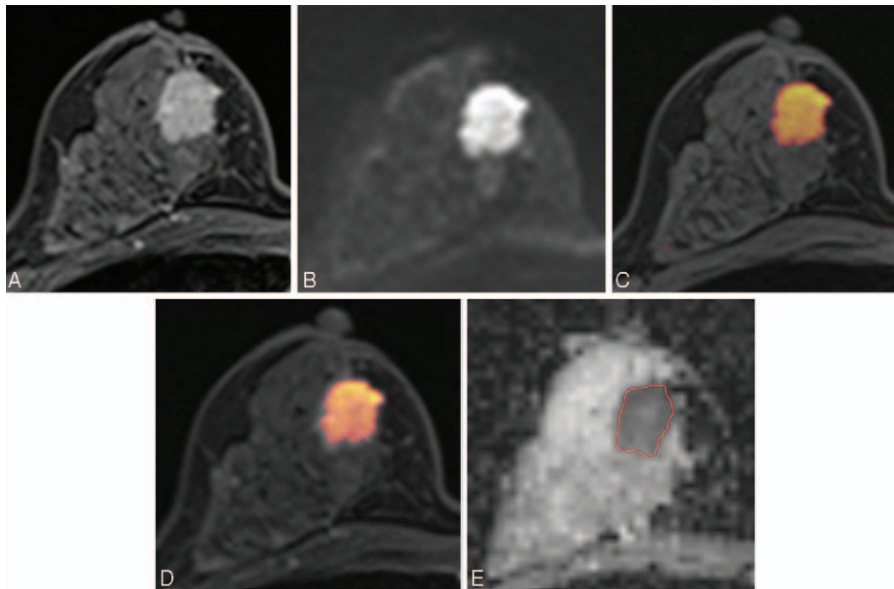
Images of a 45-y-old patient with an invasive ductal carcinoma of the right breast. (A) Axial dynamic-contrast enhanced MRI shows a 2 cm-enhancing mass in the right breast. (B) Diffusion-weighted image at 1000 s/mm² shows a high-signal intensity mass in the right breast. (C, D) For the corresponding lesion, axial UFMR (C) and PCFMR (D) also show a red-colored mass in the right breast. (E) ADC map shows a mass with low ADC value in the right breast of 0.844 × 10⁻³ mm²/s. Definitive surgery confirmed a 1.9-cm invasive ductal carcinoma. ADC = apparent diffusion coefficient, MRI = magnetic resonance imaging, PCFMR = fused diffusion-weighted imaging using early postcontrast T1-weighted imaging, UFMR = fused diffusion-weighted imaging using unenhanced T1-weighted imaging.
